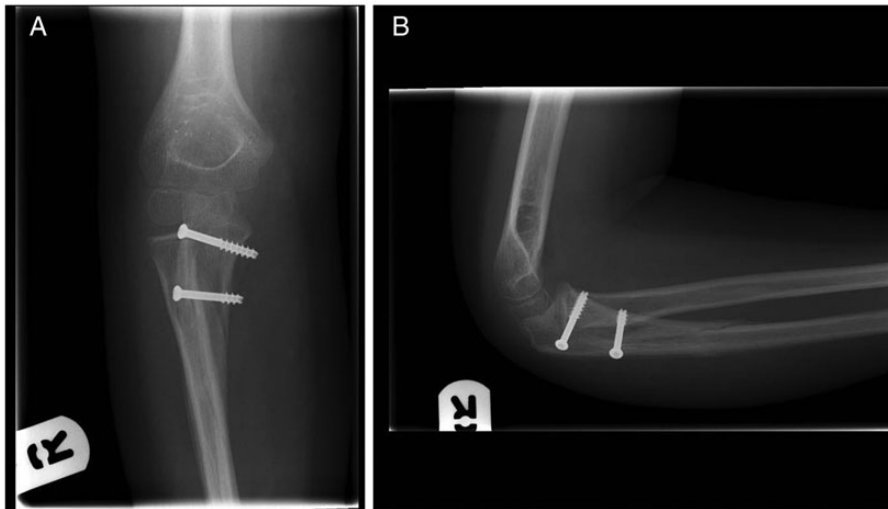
(A) Anterior–posterior and (B) lateral radiographs of the right elbow. Images taken at 5 weeks post-reduction.
